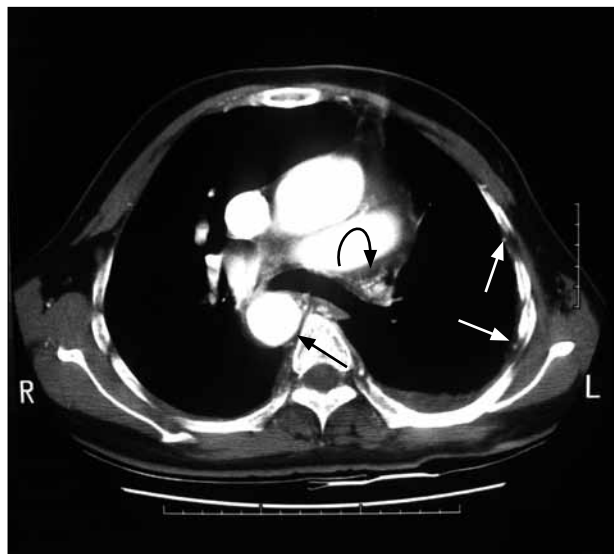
Contrast computed tomographic thorax of the second patient — at the soft tissue window. The left pulmonary artery is absent. There is an enlarged left bronchial artery (curved black arrow). Prominent left intercostal arteries (straight white arrows) are evident with associated serrated pleural thickening. There is also a right-sided aortic arch (straight black arrow) and a left pleural effusion.
